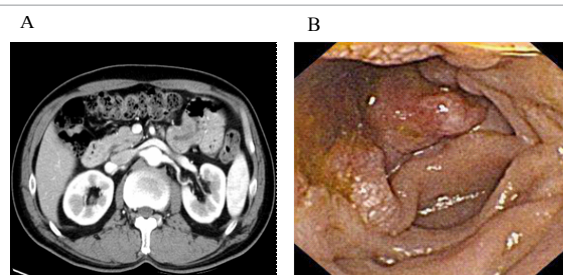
Contrast-enhanced abdominal computed tomography revealed a thickened wall in the upper jejunum (A). Capsule endoscopy (EndoCapsule®) revealed a lesion protruding two-thirds of its circumference into the upper jejunum (B).
